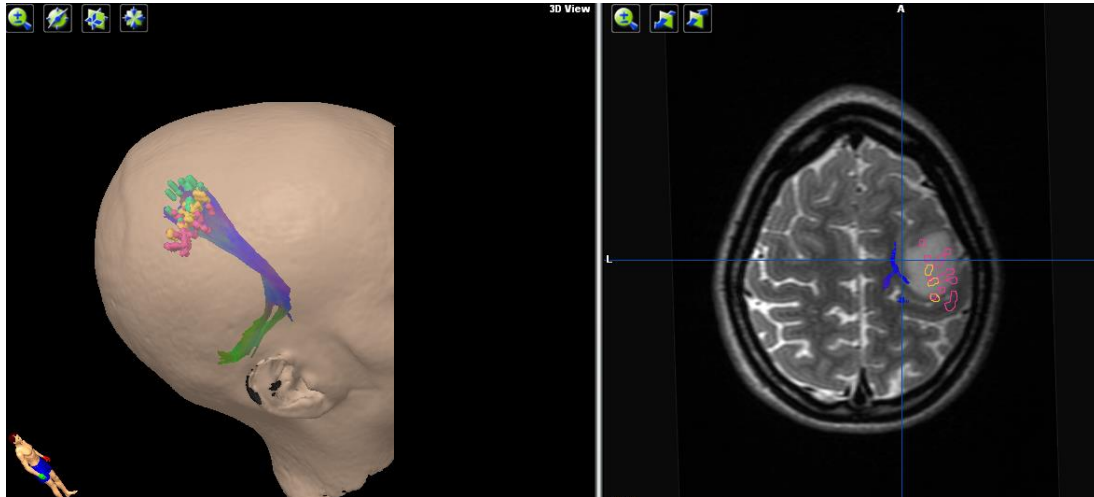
A figure capture from a neuronavigation station. Left: nTMS sites used as seeds to depict tractography. Right: nTMS sites for hand (red) and arm (orange) muscle activations drawn on the patient's MRI. Blue color indicates the tractography results Courtesy of dr. Aki Laakso.
